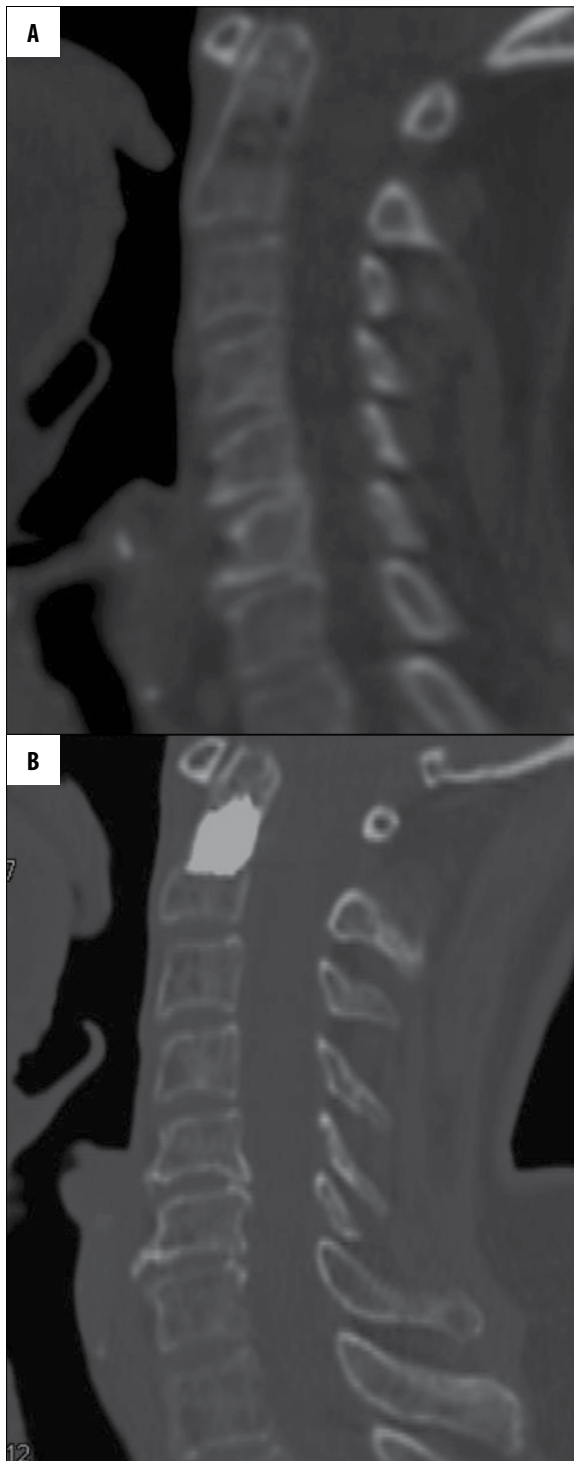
CT imaging of the cervical spine before (A, C) and after the procedure (B, D) (the same patient as in Figure 1A–1C).
